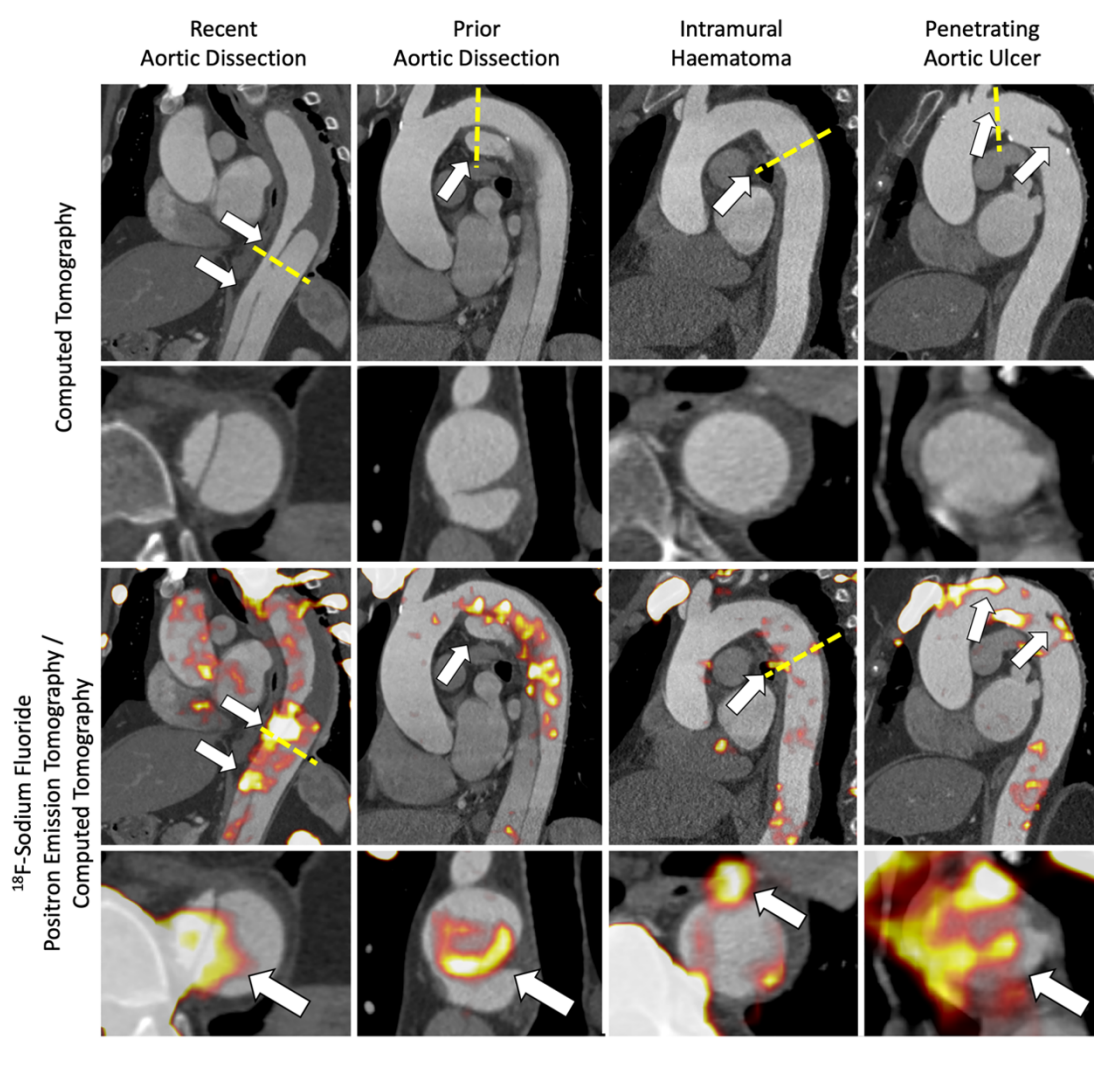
Computed tomography angiography and combined ^{18}F -sodium fluoride positron emission tomography and computed tomography in patients with acute aortic syndrome.
